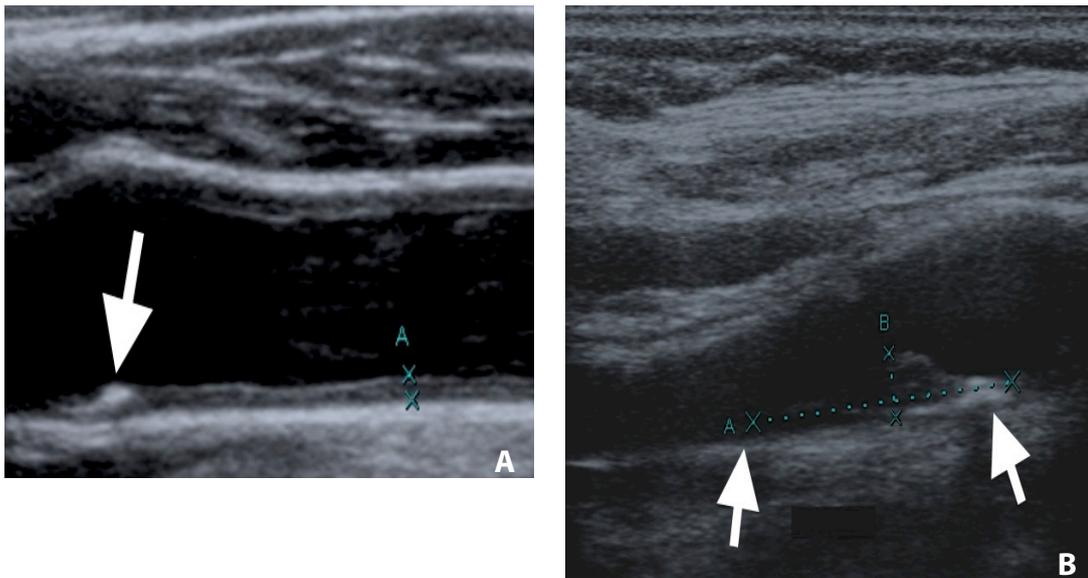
Carotid ultrasound studies of 2 asymptomatic subjects with type 2 diabetes mellitus. A) Carotid intima-media thickness measured at the far wall of the left common carotid artery (between calipers) showed diffuse increase of the IMT (1-1.2 mm). Non-significant calcified plaque in the left carotid bulb (arrow). B) Mixed non-significant plaque in the right carotid bulb and origin of the internal carotid artery (arrows).
